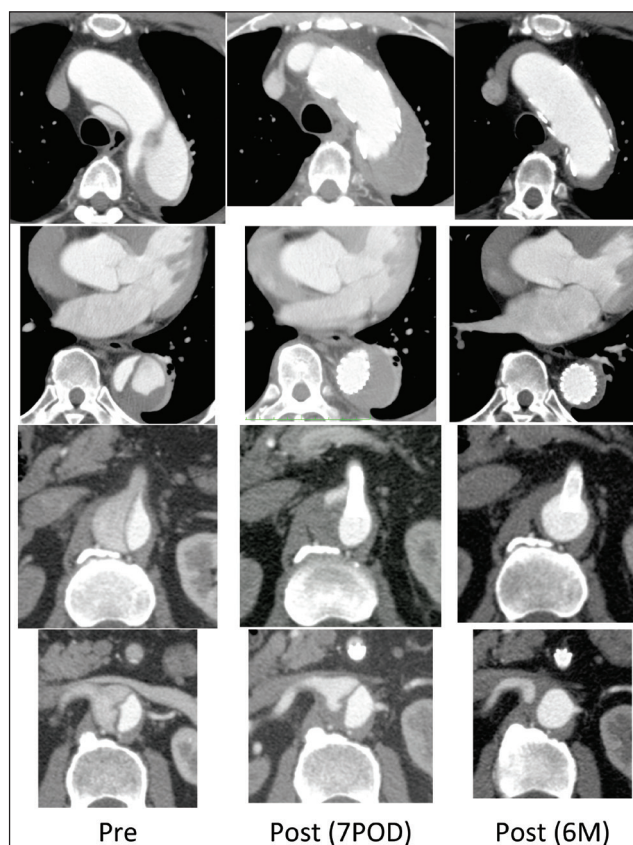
CT at preprocedure, postoperative day (POD) 4, and 6 months after the TEVAR for chronic type B dissection. Note that the false lumen eventually shrunk 6 months after the TEVAR.
